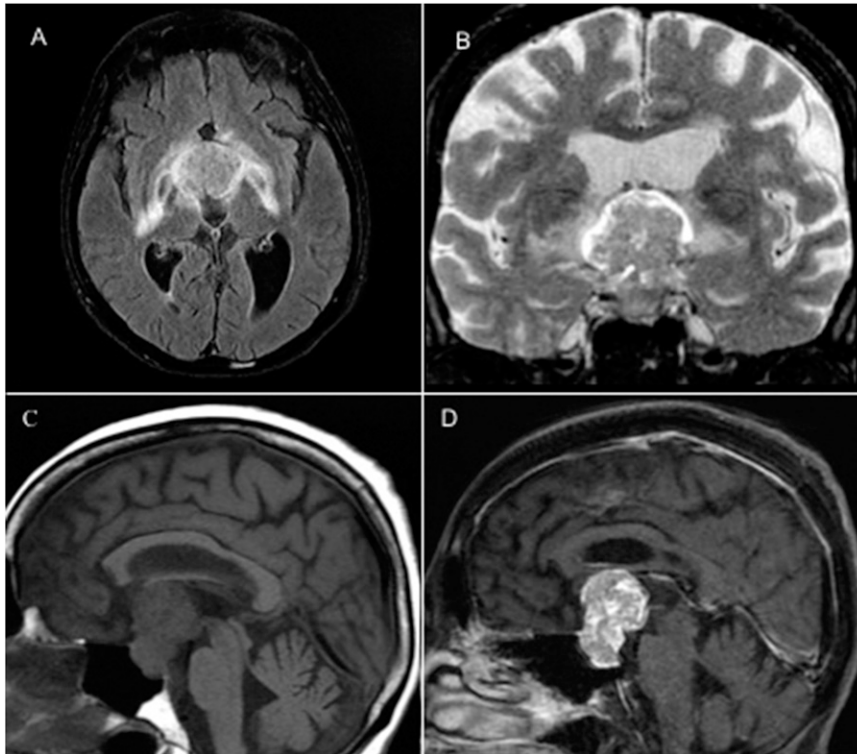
Brain magnetic resonance imaging findings. (A) Axial, (B) coronal, and (C and D) sagittal sections of (A) T2 fluid-attenuated inversion recovery, (B) T2, (C) T1 pregadolinium, and (D) postgadolinium, showing a 4-cm heterogeneous enhancing sellar and suprasellar lesion, with substantial mass effect to the chiasma and third ventricle.
